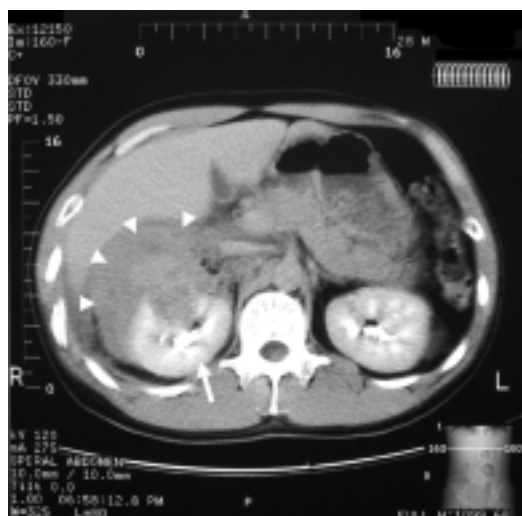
CT abdomen with intravenous contrast. The lacerated right kidney (white arrow) and the perinephric haematoma (white arrowheads) are well identified. Findings are compatible with the ultrasonography.
